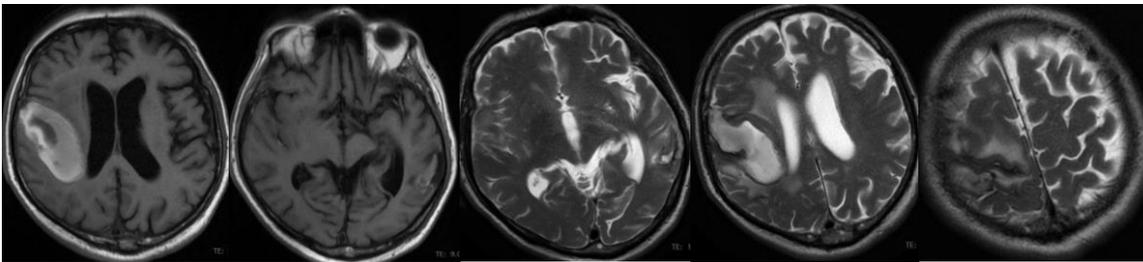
First MRI: a right pre-Rolandic lesion (blue arrow), hypointense with hyperintense ring in T1-weighted sequence (a); hyperintense in T2-weighted sequence (b); and a left temporal lesion (yellow arrow) iso to hyperintense in T1-weighted sequence (c); and hypointense in T2-weighted sequence (d)
